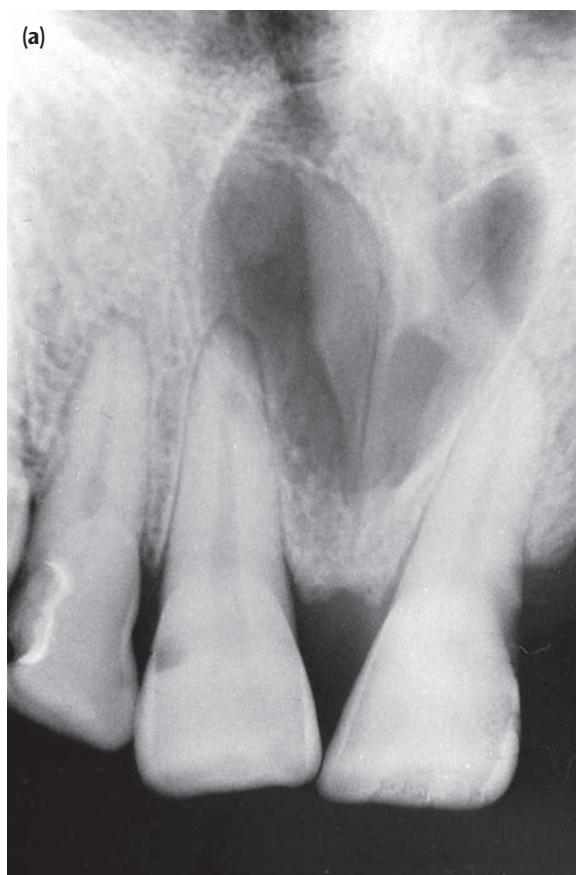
(a) Radiograph of a nasopalatine duct cyst showing a pear-shaped radiolucency in the anterior maxilla. The lamina dura on the left is intact although the apex appears to be in the cyst. (b) Shows a large round radiolucency. The roots of the maxillary incisor teeth are displaced laterally.
